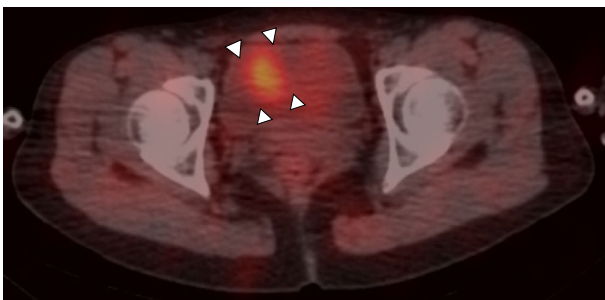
The fusion images of ^{123}I -MIBG scintigraphy and CT in the transverse section showed the accumulation in the bladder wall, which was located slightly to the right of the midline on the ventral side of the wall (white arrowhead). MIBG: metaiodobenzylguanidine
